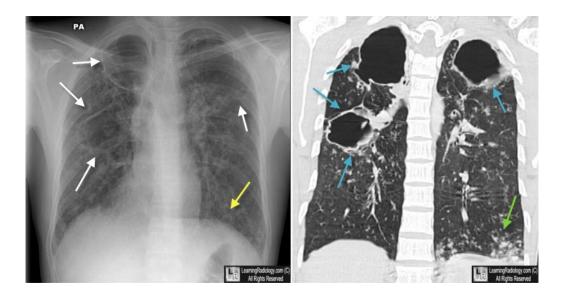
Typical image of lung cavities on chest X-ray (left image) and CCT (right image). The pictures show large cavities in both lung apices (white arrows on X-ray and blue arrows on CCT). The yellow arrow on the chest X-ray indicates an airspace disease at the left base, whereas the green arrow on the CCT image indicates a consolidation of lung tissue at the left base.
